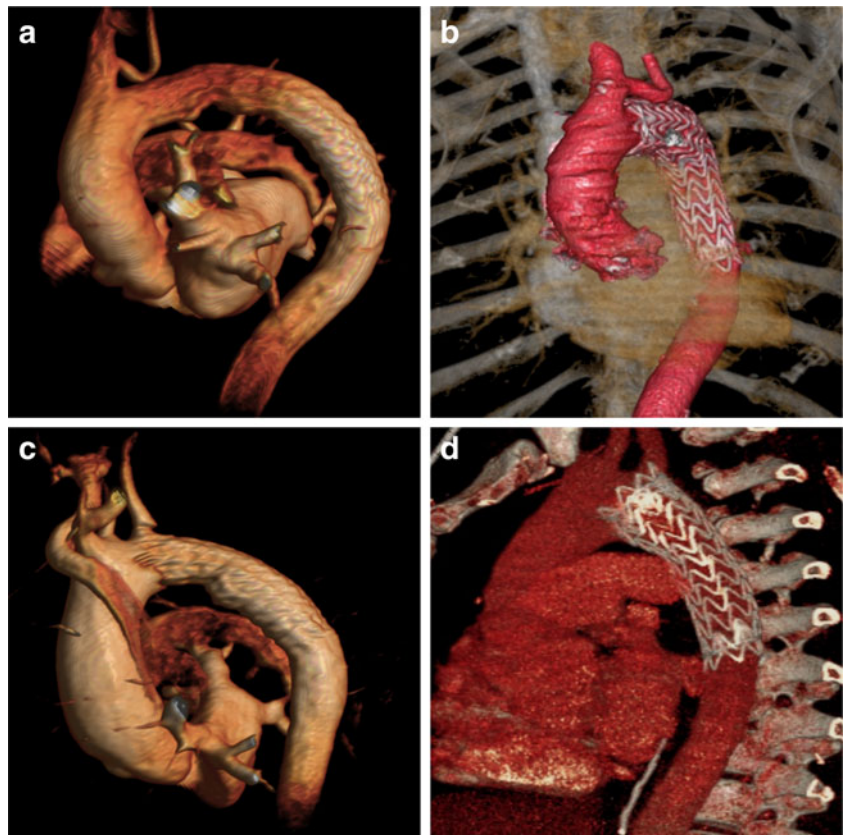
Non-contrast agent-enhanced MRI (a–c) and respective CTA (d–f) visualisation of thoracic stent grafts. Because of the different contrast mechanism, contrary to CTA the stent struts appear black on MRI
